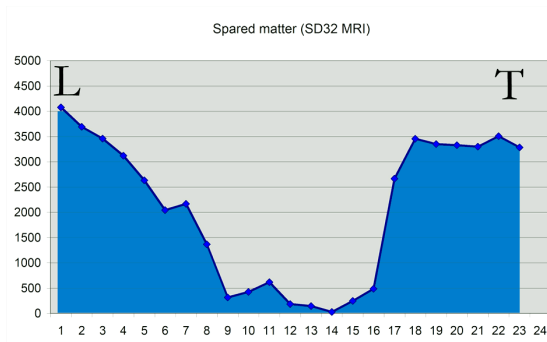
MRI PD32. Spared matter (total surface–lesion surface). X-axis: section number. Y-axis: surface (square pixels).
